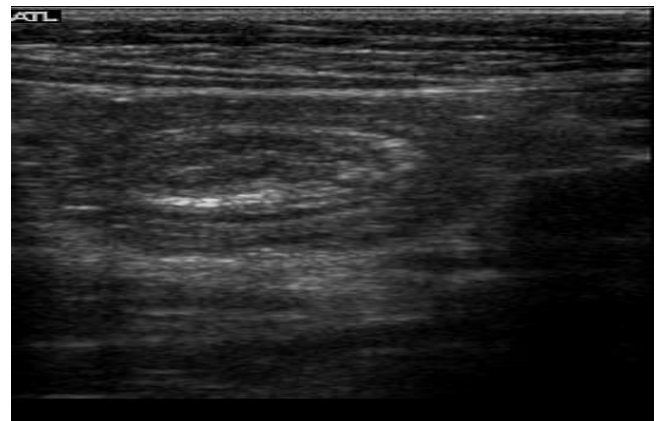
Ultrasound showing ileo-colic intussusception (target sign)
